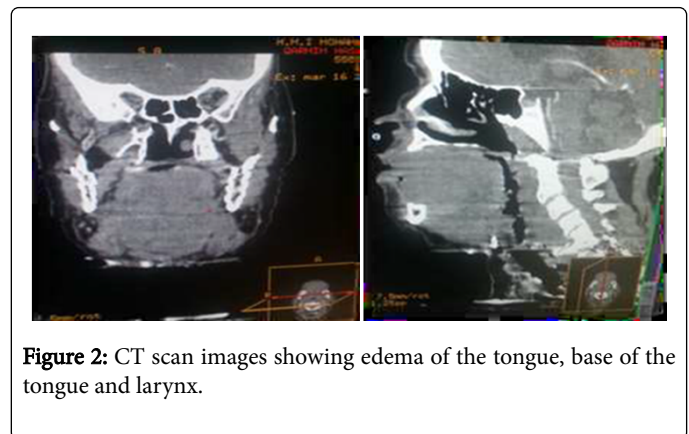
CT scan images showing edema of the tongue, base of the tongue and larynx.
